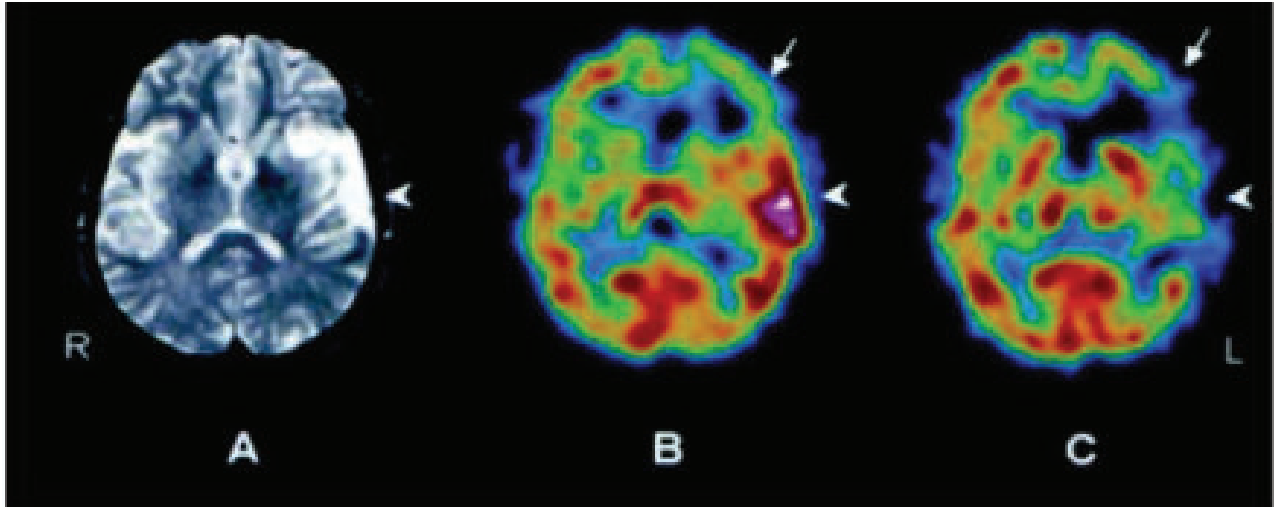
(A) MRI (T2-weighted) at admission shows hyperintensity at site of infarction (arrowhead). (B) ^{99m}Tc -HMPAO SPECT image obtained 1 wk after stroke shows increased tracer uptake (hyperperfusion) in left temporal lobe caused by luxury perfusion (arrowhead). Hypoperfusion is also seen in left frontal cortex (arrow), interpreted as ischemia in anatomically preserved region. (C) ^{99m}Tc -HMPAO SPECT image obtained 1 mo after stroke shows left temporal lobe hypoperfusion (arrowhead) corresponding to initial MR image of ischemia. Perfusion changes in left frontal lobe are also seen: improvement in anterior and mesial aspects caused by recovery of ischemia, as well as perfusion impairment in lateral aspect caused by extension of the infarction (arrow).
